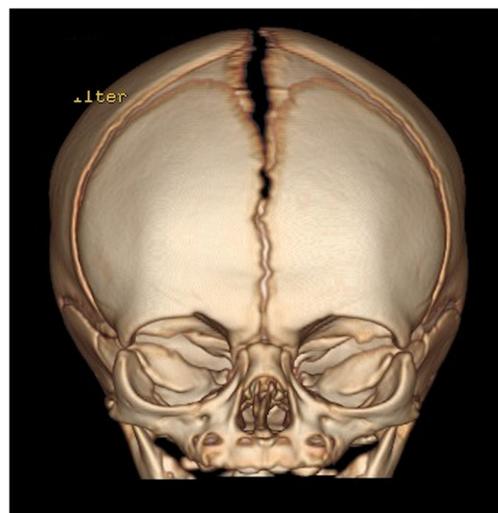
A 3D CT scan of a patent metopic suture in a 25-day-old patient, the entire length of the metopic suture from glabella to the anterior fontanel can be clearly seen
